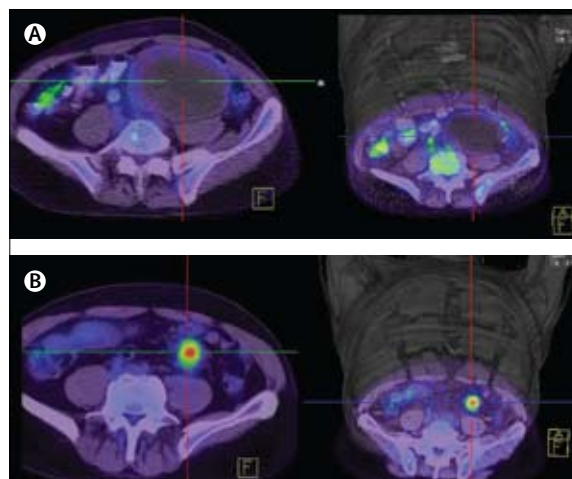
FDG-PET-CT therapeutic monitoring of GIST
